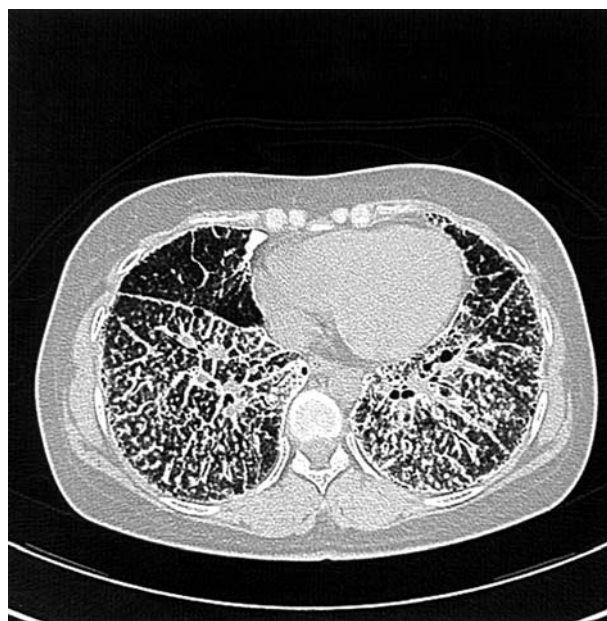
Coronal section of high resolution computed tomography of chest showing bilateral intra-lobular interstitial and septal thickening with dense calcification. Also note small subpleural cysts on both sides.
